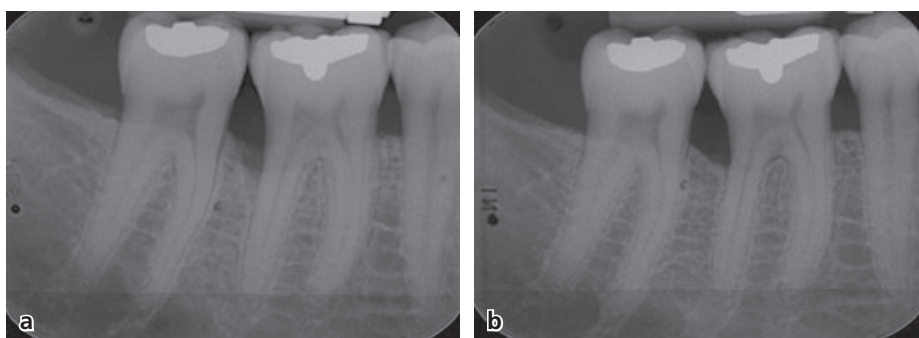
Radiographs before (a) and after (b) periodontal regeneration of the angular bony defect on the distal aspect of tooth 46.
